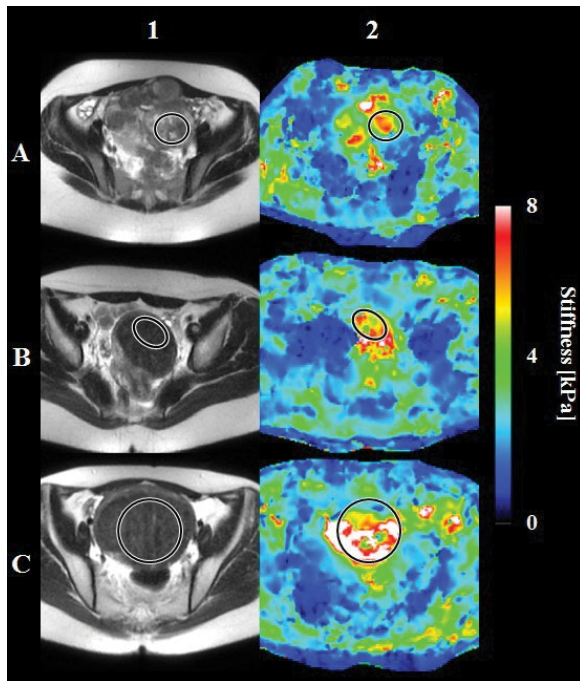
T2w MR images (column 1) and comparison of elastograms (column 2) for patient 6 (row A), 9 (row B) and 3 (row C). The mean stiffness was 3.95 kPa, 4.68 kPa and 6.9 kPa for the above mentioned patients, respectively
